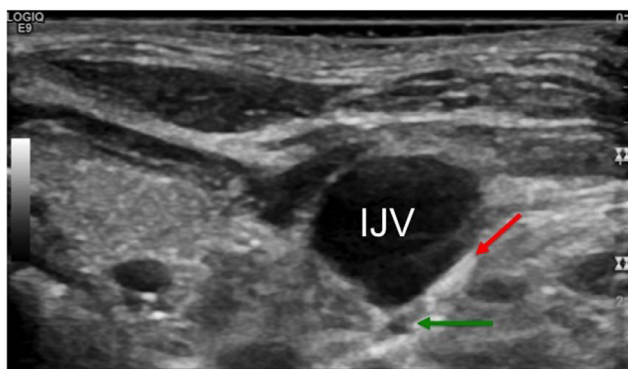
Ultrasound-guided transcervical needle-access to the thoracic duct near the junction of left internal jugular vein (IJV) and subclavian vein. red arrow = needle tip; green arrow = thoracic duct.
